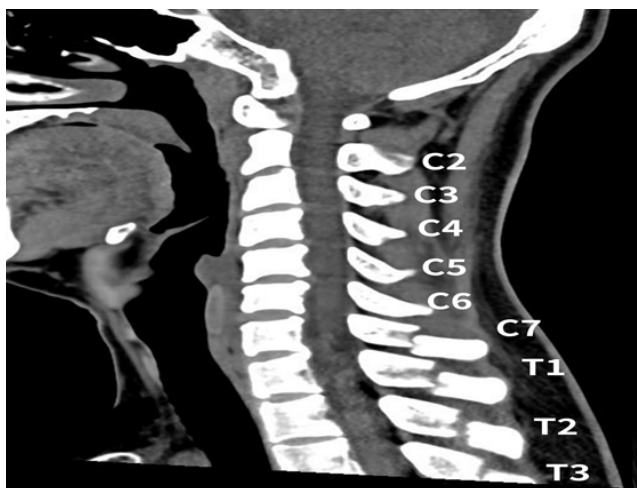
Cervical spine computed tomography (lateral view)
